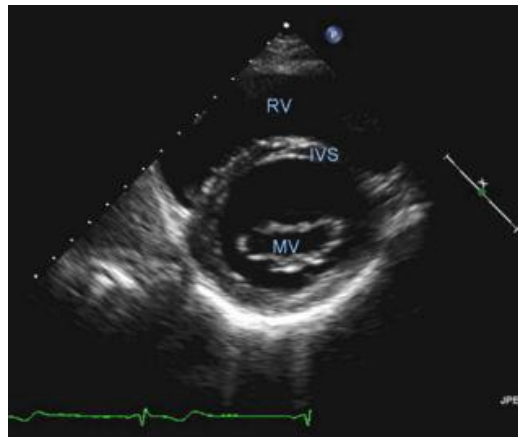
18) Normal parasternal short axis view .(Feigenbaum2010)
